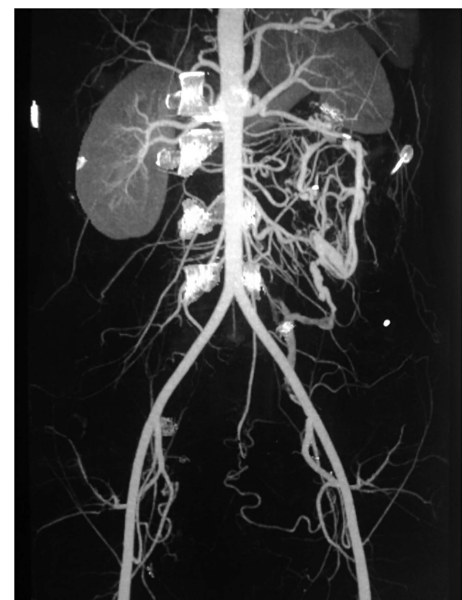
CT angiogram showing heterogeneously enhancing soft tissue lesion with multiple dilated tortuous vascular channels involving layers of posterior abdominal wall, compressing and displacing the left kidney anteriorly and superiorly.
